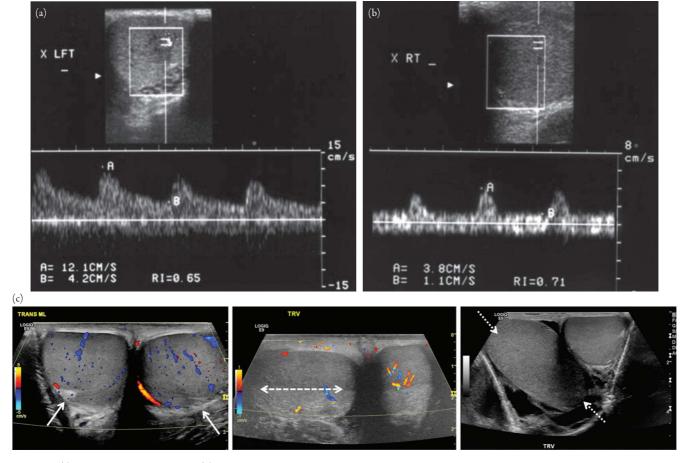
(a) Normal flow in the testis. (b) Increased resistive index with reduced diastolic flow in a patient with testicular torsion. Adapted from Figure 4 of Dogra VS, Rubens DJ, Gottlieb RH, Bhatt S. Torsion and beyond: new twists in spectral Doppler evaluation of the scrotum. *J Ultrasound Med.* 2004;23(8):1077–1085. (c) Testicular lie. (A) Color Doppler transverse ultrasound (US) image of normal vertical lie with the mediastinum testis (arrows) directed posterolaterally. (B) Color Doppler transverse US image of both testes demonstrating abnormal horizontal lie of the right testis (perforated arrow) with slightly decreased intratesticular flow compared to the normal left side. (C) Grayscale transverse US image demonstrating abnormal oblique lie of the right testis (dotted arrows), which is oriented diagonally compared to the normal left side. Adapted from Figure 5 of Bandarkar AN, Blask AR. Testicular torsion with preserved flow: key sonographic features and value-added approach to diagnosis. *Pediatr Radiol.* 2018;48(5):735–744. doi:10.1007/s00247-018-4093-0.
